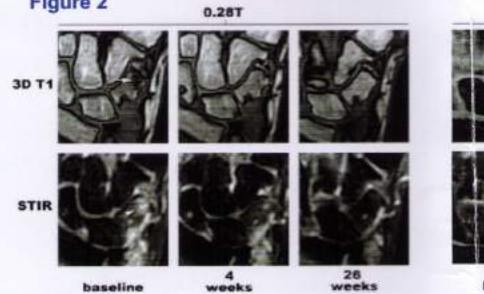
MRI of the carpus revealed osteitis (arrowheads) in the triquetrum and distal pole of the triquetrum which regressed at 4 weeks. The conspicuity of osteitis was similar on the 0.28T and 1.5T MRI STIR sequences with fat suppression.
